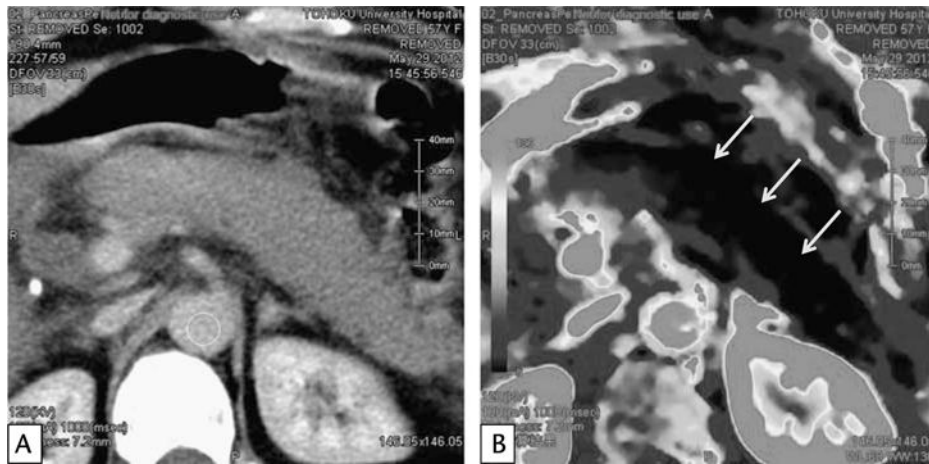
Perfusion CT 12 hours after the onset of severe pancreatitis. Perfusion CT can detect pancreatic and peripancreatic ischemia. A, On a contrast enhanced CT, the pancreas appears homogeneously enhanced. B, Perfusion CT shows slower blood flow in the pancreas (arrows) as seen by the lack of perfusion.
